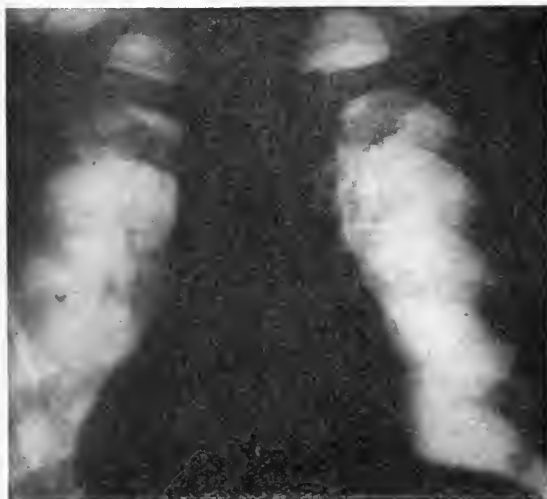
Claus H. Roentgenogram taken May 16, 1920, on discharge. (The plate is reversed).
